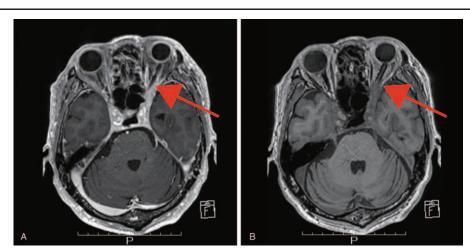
Transverse MRI images at second-time admission showing involved lesion in left optic canal (red arrowhead). (A) T1-weighted image. (B) T2-weighted image.
